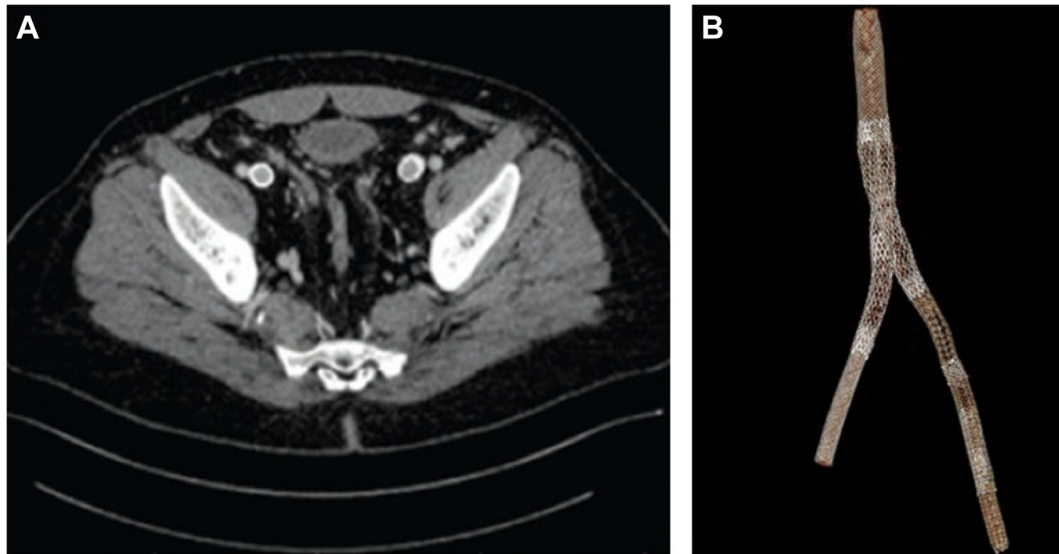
(A and B) Axial view of 1-month follow-up computed tomography (CT) venogram with confirmation of iliocaval stents patency. Three-dimensional postoperative reconstruction of percutaneous mechanical thrombectomy.
